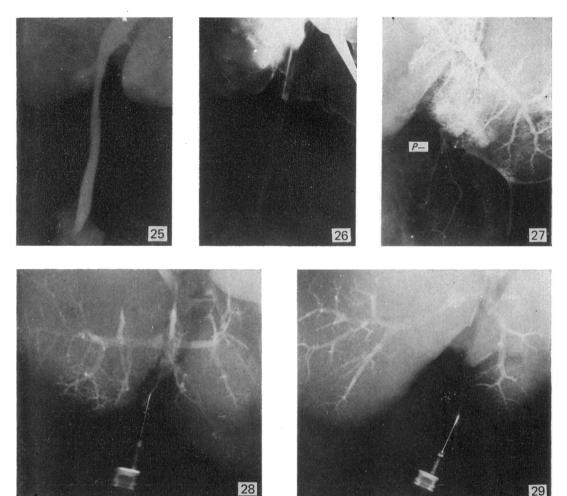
Umbilical vein; $1\frac{1}{2}$ days. The wide lumen is filled as far as the umbilicus by retrograde injection. All radiographs were taken following injection of the contrast medium 'Hypaque'. Fig. 26. Umbilical vein; 77 years. Retrograde injection shows a small residual lumen in only the upper third of the vein, but its diameter is similar to that in the child. Fig. 27. Sappey's inferior veins; 93 years. Retrograde filling shows a plexus (P) formed by the terminal channel at the liver margin which communicates with the quadrate lobe (See Fig. 6). Fig. 28. Sappey's inferior veins; 67 years. Direct injection of the main channel shows that in this case it communicates with the portal system after ascending in the umbilical fissure (see Fig. 3). Fig. 29. Sappey's inferior veins; 70 years. Direct injection of the main channel in this case shows that it communicates directly with the portal system within the quadrate lobe (see Figs. 6 & 7).
